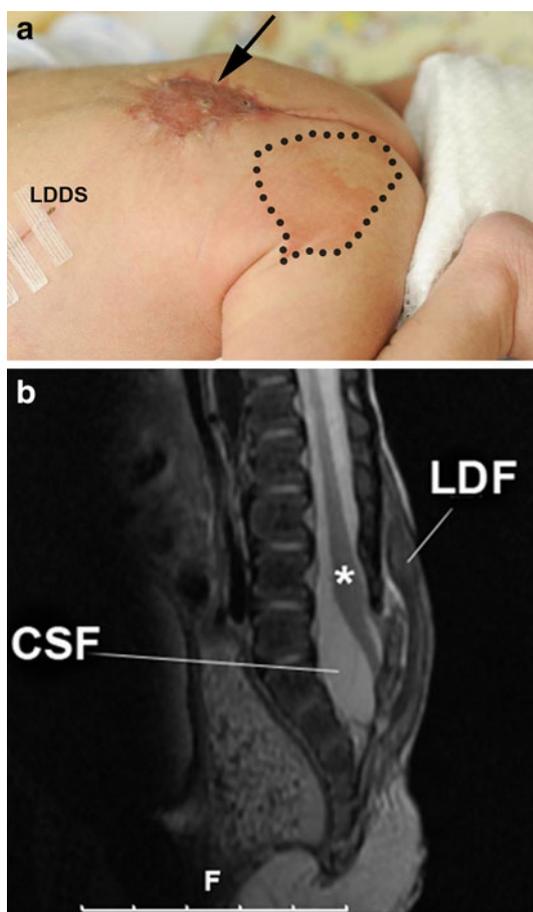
a Perfectly healed repair site (*arrow*) 3 weeks after performing the reverse latissimus dorsi coverage and split thickness skin grafting. *LDDS* latissimus dorsi donor site, *dotted line* split skin donor site. b Postnatal MRI obtained 3 weeks post birth. *Asterisk* spinal cord, *CSF* cerebrospinal fluid, *LDF* latissimus dorsi muscle flap
